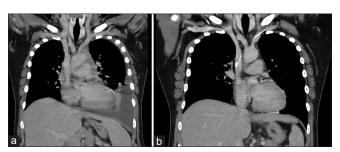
(a) Coronal computed tomography image at diagnosis, revealing mediastinal lymphadenopathies with encasement of the great vessels and left side pleural effusion. (b) Coronal computed tomography image after the 6^{th} cycle of CHOP: Cyclophosphamide, vincristine, doxorubicin, prednisolone
